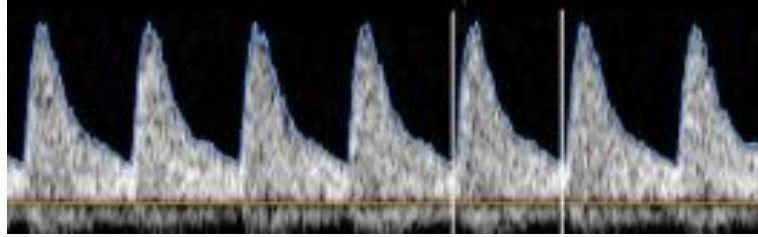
FIGURE IB: NORMAL DOPPLER WAVEFORM OF MIDDLE CEREBRAL ARTERY
